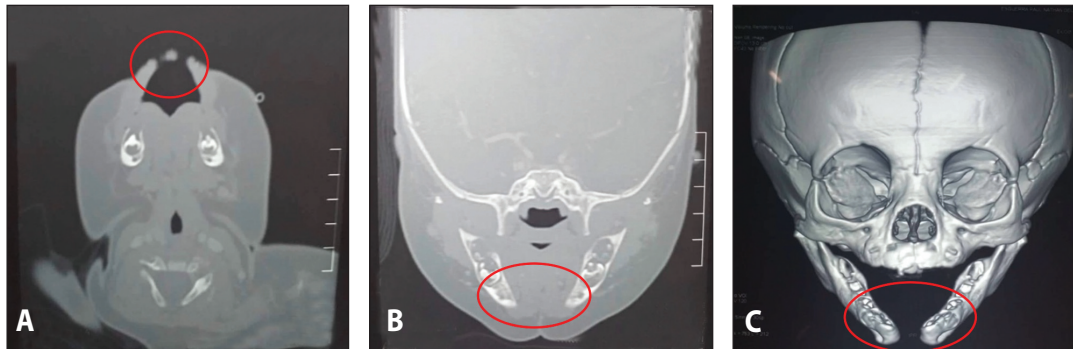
CT scan images A. axial view, B. coronal view, and C. 3D Reconstruction images showing (encircled) median mandibular cleft with widely separated symphysis menti and midline soft tissue defects of the lower lip, anterior portion of the oral tongue (at the frenulum) and subjacent floor of the mouth.
